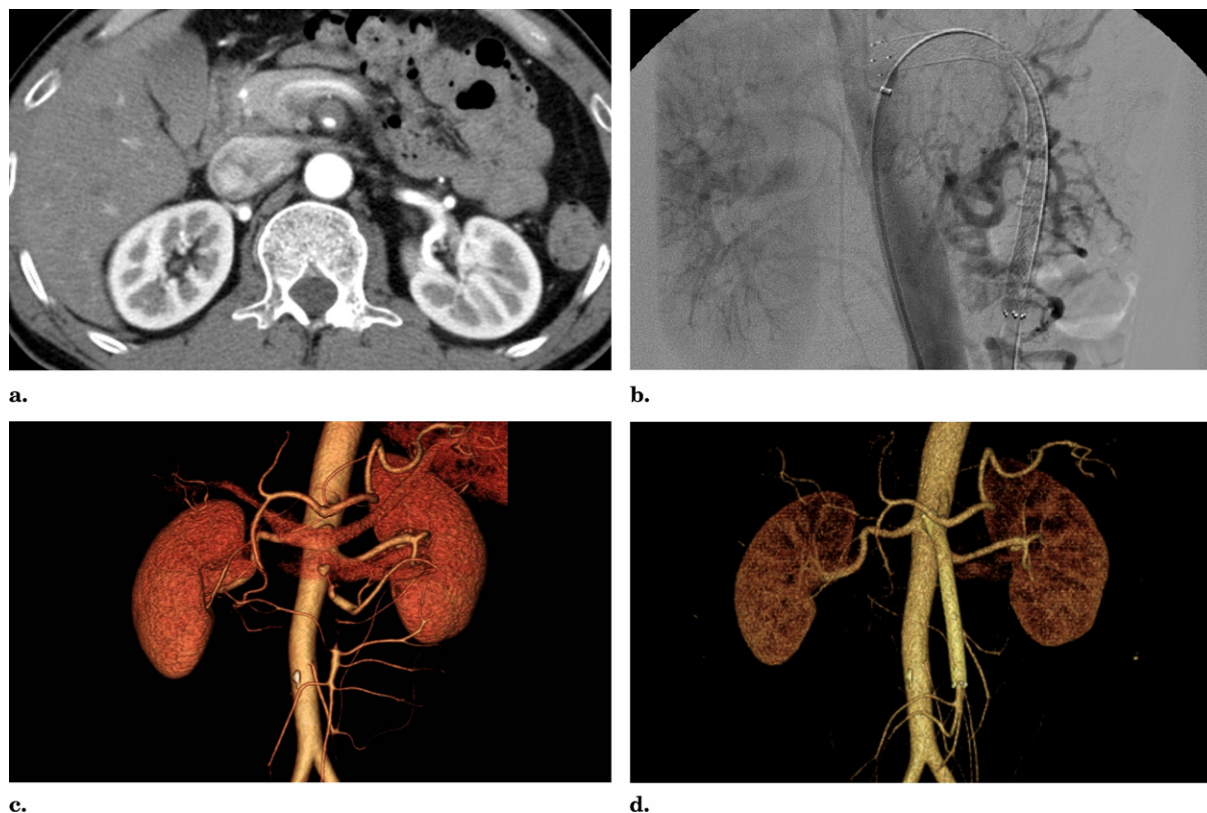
(a) Abdominal CT scan demonstrates SMA dissection with thrombosed false lumen. (b) Percutaneous transcatheter angioplasty was performed by deployment of an 8-mm \times 100-mm self-expandable stent. Follow-up three-dimensional volume-rendered images demonstrate good patency of the stent initially after endovascular treatment (c) and at 6 months (d). (Available in color online at www.jvir.org.)
